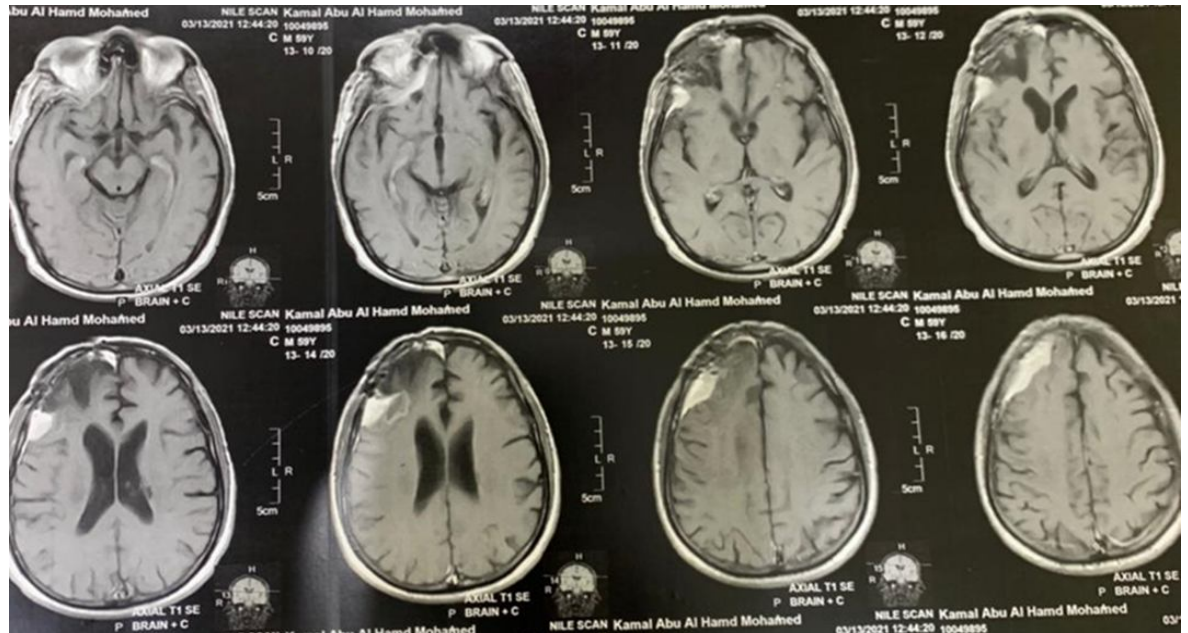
Postoperative CT brain
